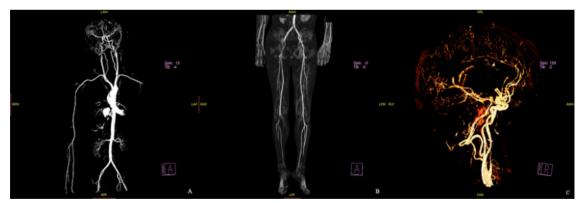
Post-mortem CT angiography*
